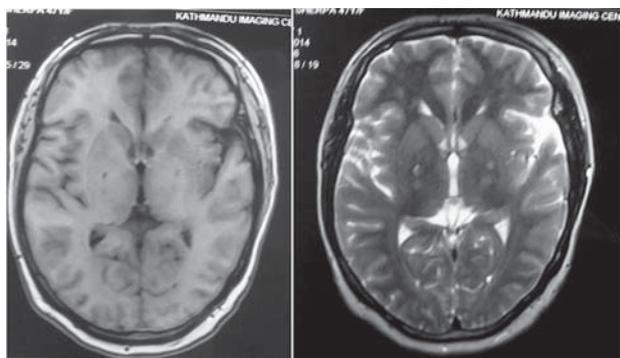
Postoperative MRI Brain After three months; T1W and T2W Axial Images:
